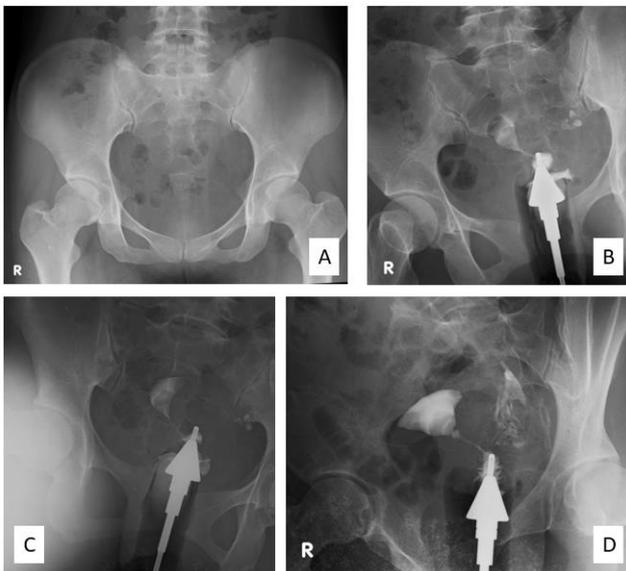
Adenomyosis. (A) Plain X-ray. (B) (C) (D) Contrast appears filling the cervical canal, uterine cavity, and left fallopian tube, which then backflows and fills the proximal vagina. The cervical canal is normal, with regular edges. The uterine cavity is in an anteflexed position, with smooth mucosa, and no additional shadow is visible. Multiple filling defects in the form of ovoid shapes with lobulated edges are seen in the distal uterine cavity, left uterine fundus, and right uterine horn.
